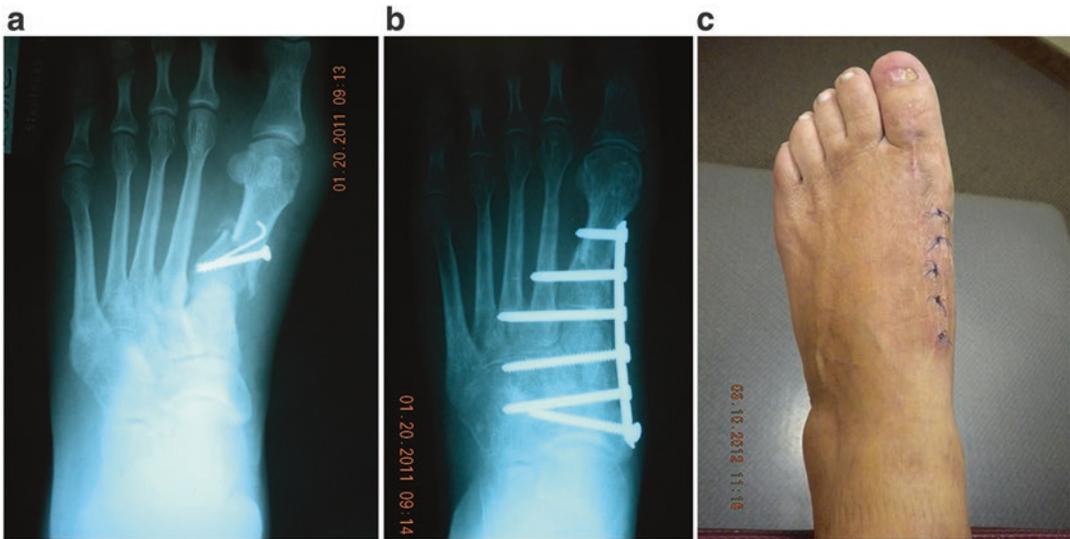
(a) This is an AP radiograph of a patient who underwent a closing base wedge osteotomy of the first metatarsal with K-wire and screw fixation. The patient experienced a fracture and displacement of the osteotomy site with malalignment. (b) This is an AP radiograph of correction of photo 12 A who underwent a revision Lapidus procedure to correct the malalignment and displacement of the closing base wedge osteotomy. (c) A
